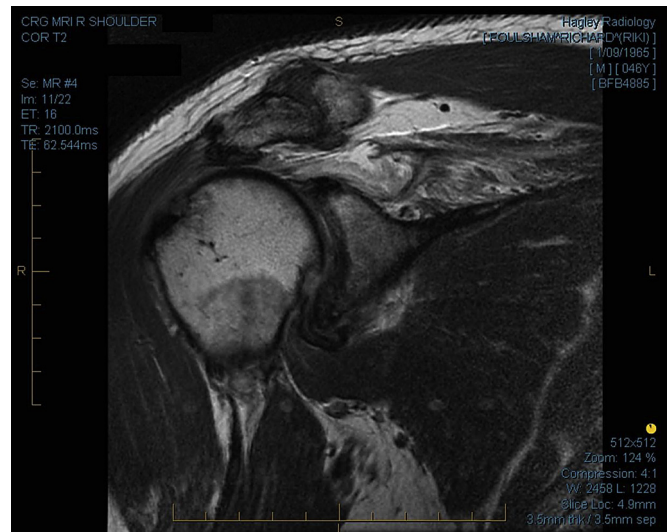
MRI of the shoulder demonstrating severe (Goutallier Grade 4) fatty degeneration of supraspinatus in a chronic irreparable rotator cuff tear.
